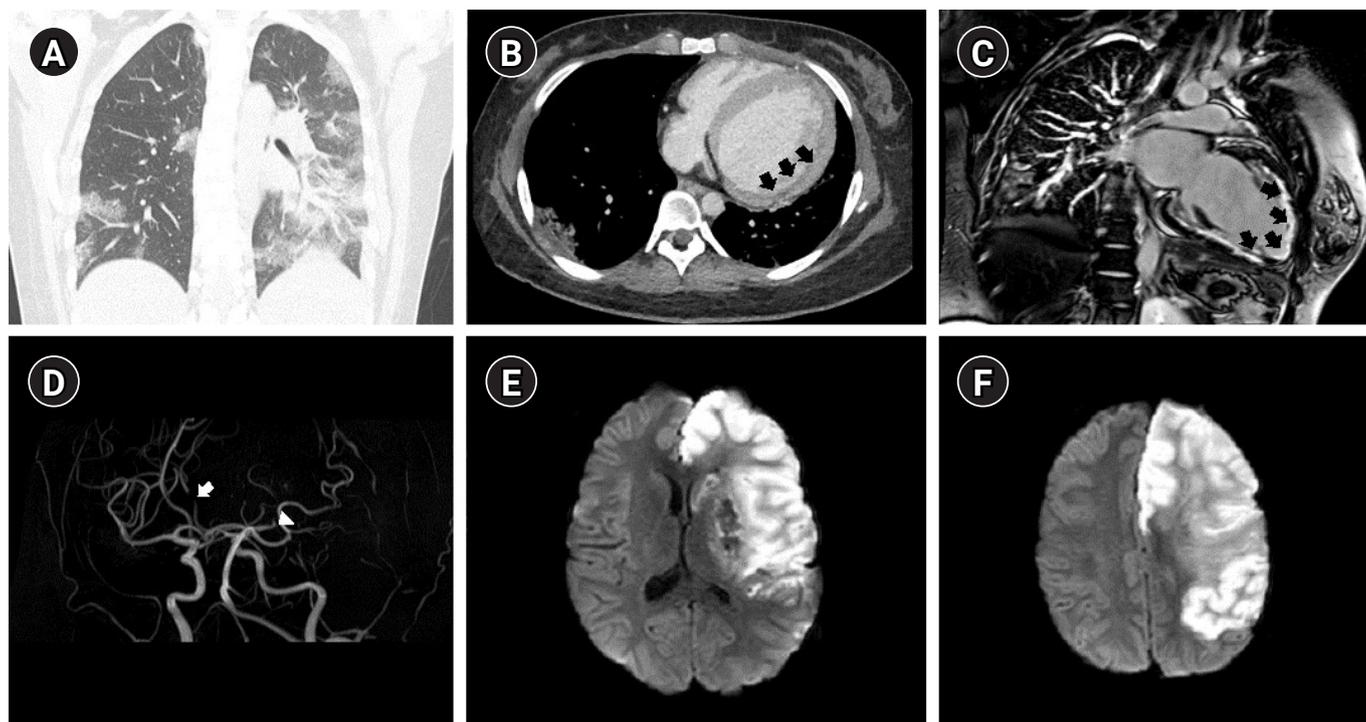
(A) Chest computed tomography showing multifocal consolidation with ground-glass opacities in both lungs. (B) Cardiac magnetic resonance imaging showing a hypertrophied myocardium due to edema (black arrows). (C) Cardiac magnetic resonance imaging showing transmural late gadolinium enhancement (black arrows). (D) Brain magnetic resonance angiography showing the severe stenosis of the left A2 segment of the anterior cerebral artery (ACA; white arrow) and the distal segment of the left middle cerebral artery (MCA; white arrowhead). (E, F) A diffusion-weighted image showing high signal intensity in the left MCA and ACA territory infarction.
